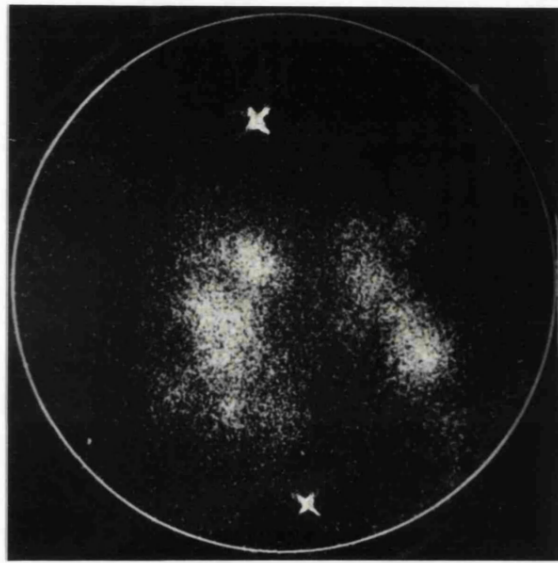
Antero-posterior gamma camera scintigram of chest following therapy with 5.5 GBq ^{131}I showing bilateral uptake in the lungs due to multiple micronodular metastases.
